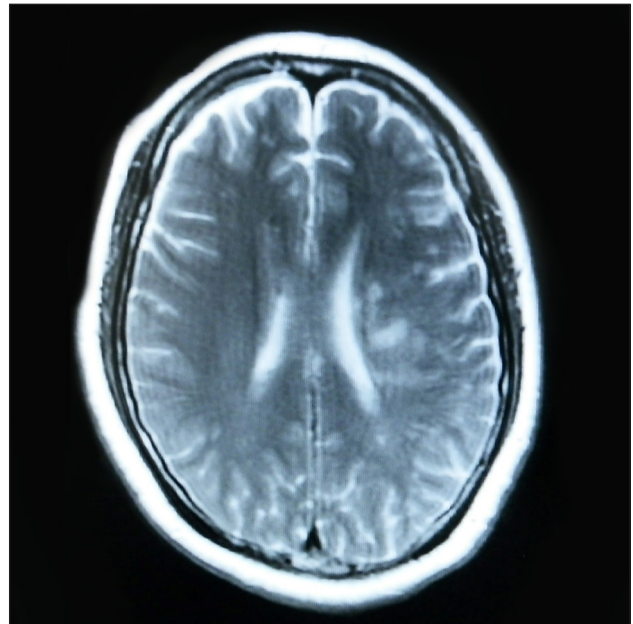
Axial T2-weighter magnetic resonance imaging on august 11 2009, revealing infarcts larger than they were 20 days before
